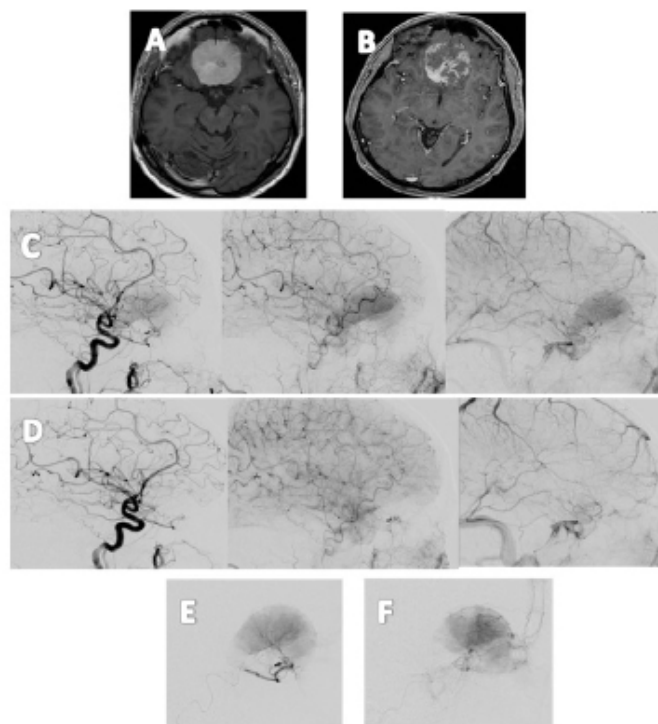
A case with olfactory groove meningioma A) Pre-embolization MRI axial T1 with contrast shows homogenous tumor enhancement, B) Post-embolization MRI axial T1 with contrast shows tumor necrosis with capsular enhancement, C) Pre-embolization common carotid artery (CCA) angiogram in different phases shows tumor blush, D) Post-embolization CCA angiogram in different phases shows disappearance of tumor blush, E) Selective catheterization of the ophthalmic artery shows retinal blush, F) Super-selective catheterization of the posterior ethmoidal artery with no retinal blush seen.
